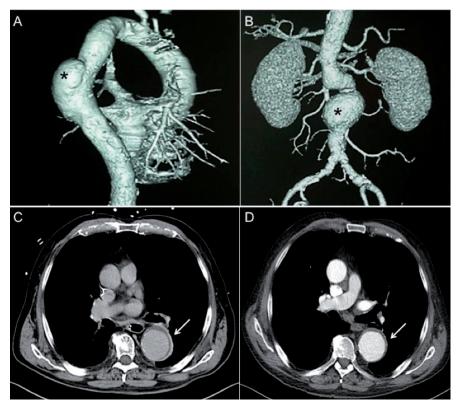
Computed tomography angiography of thoracic (A) and infra-renal abdominal (B) aortic aneurysms (*). Vessel wall thickening with contrast enhancement in the descending thoracic aorta, indicating aortitis, was identified before starting glucocorticoid treatment (C). After 2 years of treatment, reduction in the aortic wall thickening and disappearance of the contrast enhancement was observed (D).
